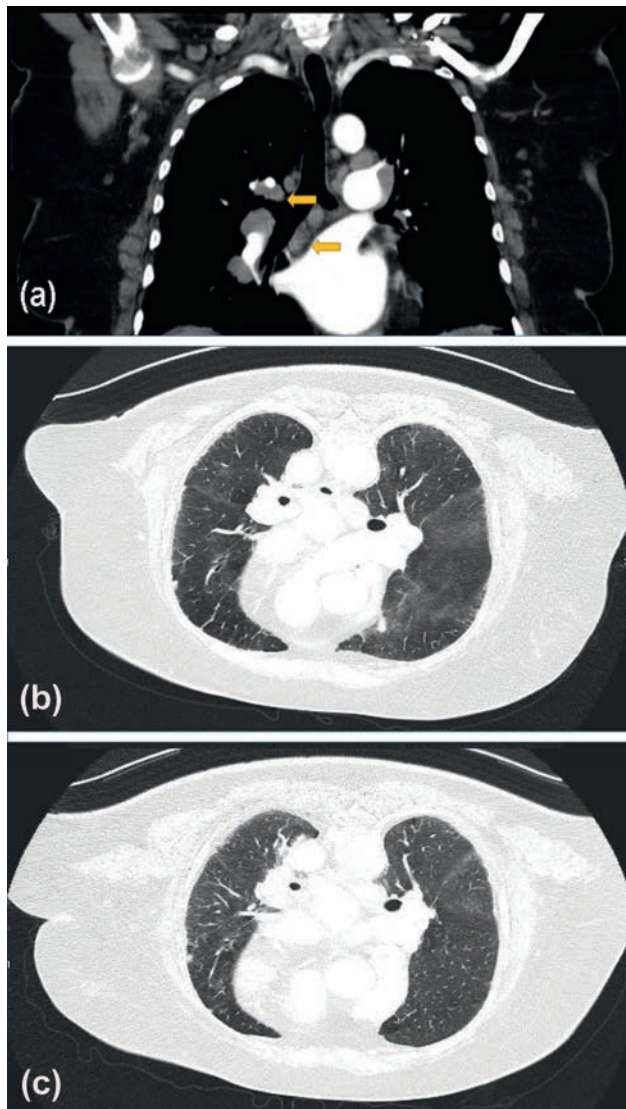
Chest computed tomography showing mediastinal and hilar lymphadenopathy (a) as well as ground glass opacities and subpleural reticulation in the lungs (b) of a patient with advanced cutaneous squamous cell carcinoma treated with anti-PD-1 agents. Three months later, almost complete resolution of the ground glass opacities (c).
